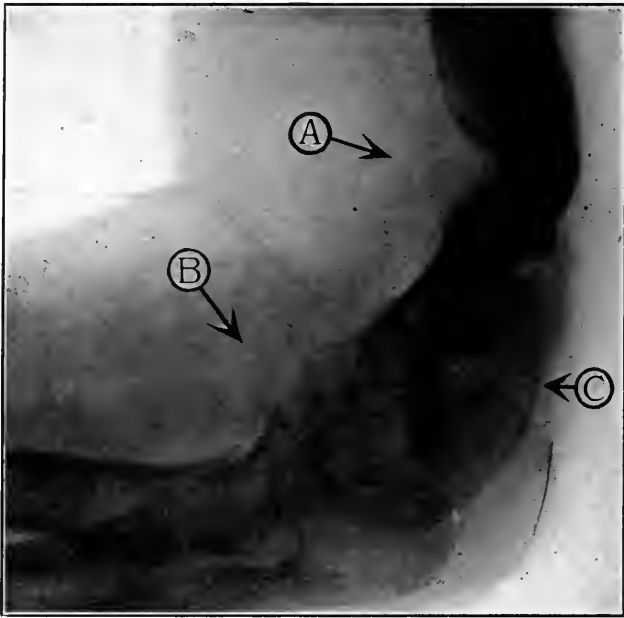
X-ray of elbow. *A*, points to refracture of supracondylar fracture humerus which occurred while patient was playing billiards (muscular action). *B*, points to solidly ankylosed elbow-joint resulting from fixation in a splint for six months. *C*, points to callus overgrowth in olecranon fossa which might have been prevented by early movement; the cause in this case of ankylosis, poor callus and refracture may be attributed to long-continued sepsis, which might have been eliminated early had all non-viable fragments been removed; thus the elbow could have had passive movement and ankylosis might have been avoided. (Case seen in consultation—not treated by author.)
